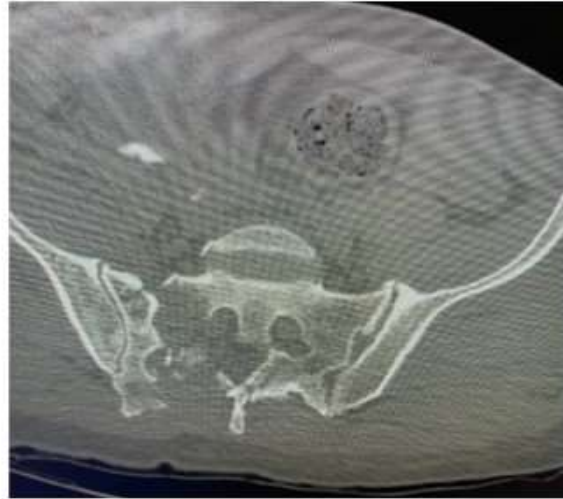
Case 3. Left side: The x-ray depicts the open pubic symphysis and difference in height of the hemipelvis. Something happens in the sacrum.
